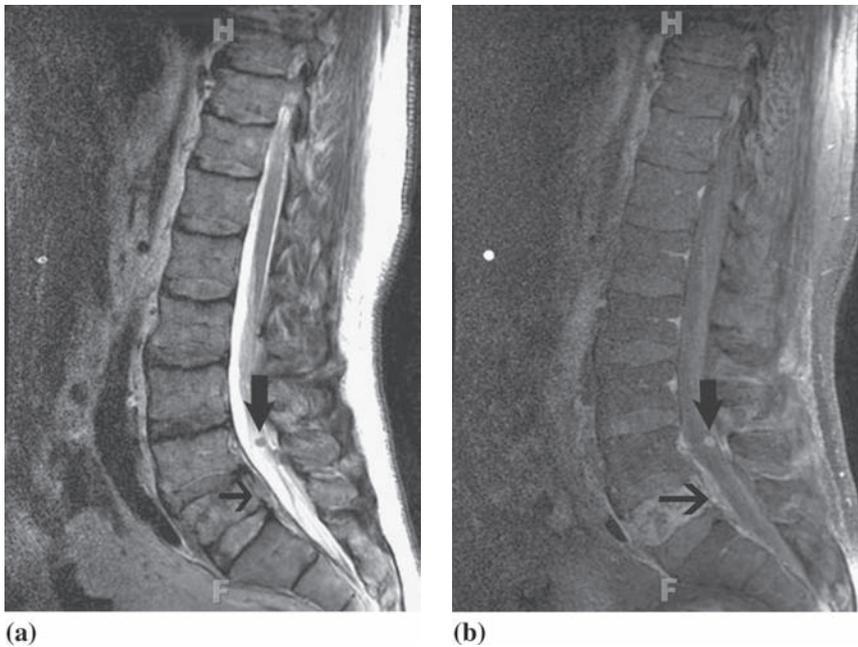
Metastatic B-cell lymphoma. (a) Sagittal T2-weighted MR image shows slight heterogeneous signal in L5 vertebra, soft tissue mass in the anterior epidural space (thin arrow) and a small hypointense nodule within the thecal sac adjacent to cauda equina roots at L4 level (arrow). (b) Contrast-enhanced fat-saturated T1-weighted sagittal image reveals bone marrow metastasis in L5 showing diffuse heterogeneous enhancement with an enhancing soft tissue component in the anterior epidural space (thin arrow) and intradural extramedullary metastatic nodule also showing enhancement (arrow)
